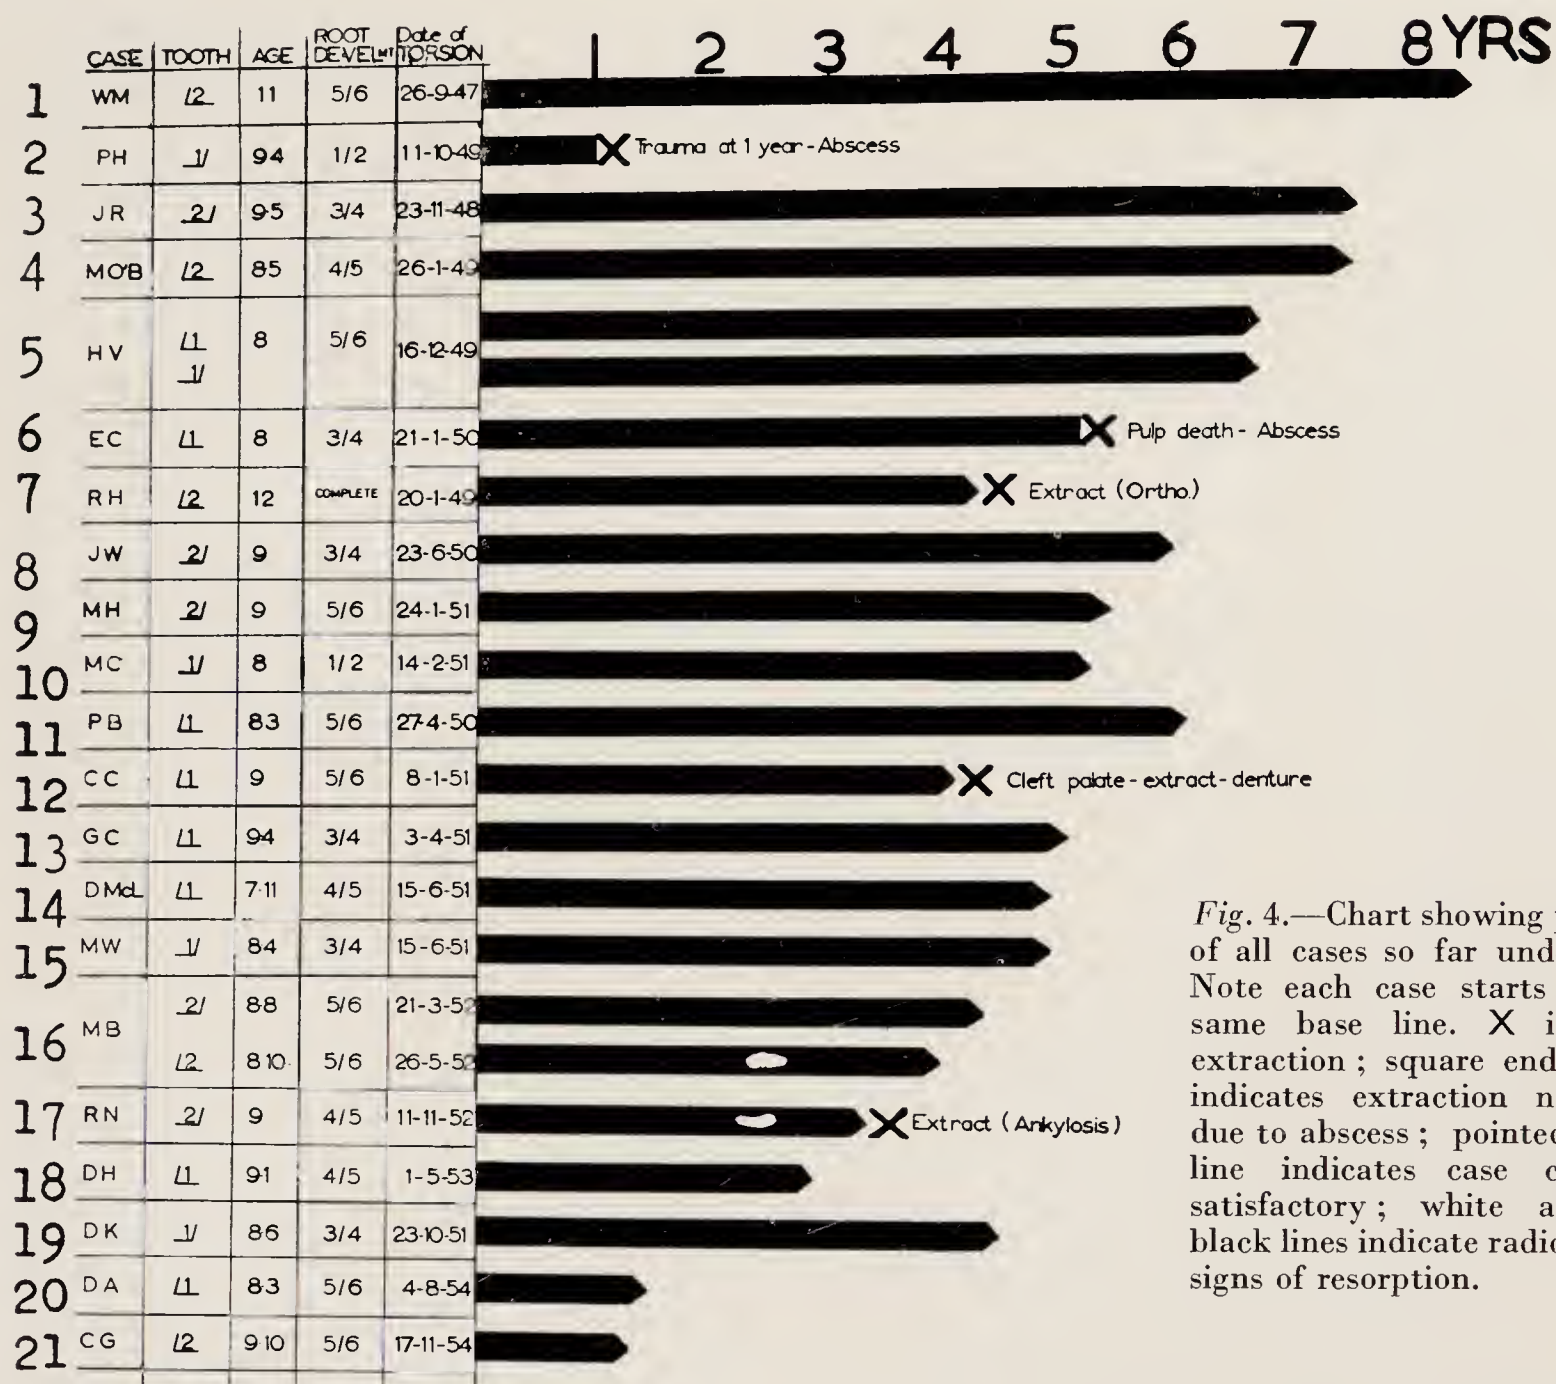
Chart showing progress of all cases so far undertaken. Note each case starts on the same base line. X indicates extraction; square end to line indicates extraction necessary due to abscess; pointed end to line indicates case clinically satisfactory; white areas in black lines indicate radiographic signs of resorption.
